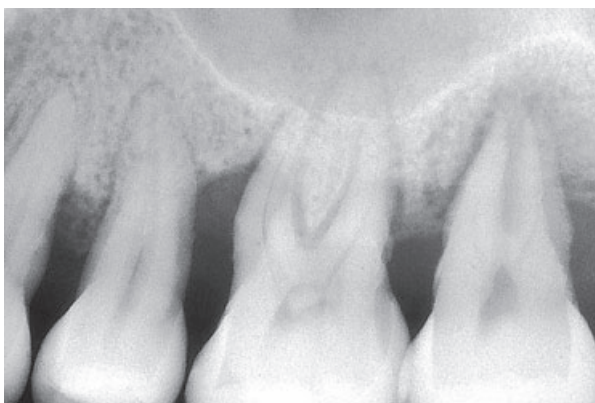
Radiograph showing maxillary molars with thin, short, and conical roots.
